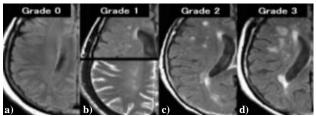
Deep white matter hyperintensity (DWMH) grading of magnetic resonance images (12), a) grade 0, no lesion, b) grade 1, in the form of punctate, c) grade 2, punctate hyperintensity prone to fusion, d) grade 3, large confluent and enlarged punctate hyperintensity
